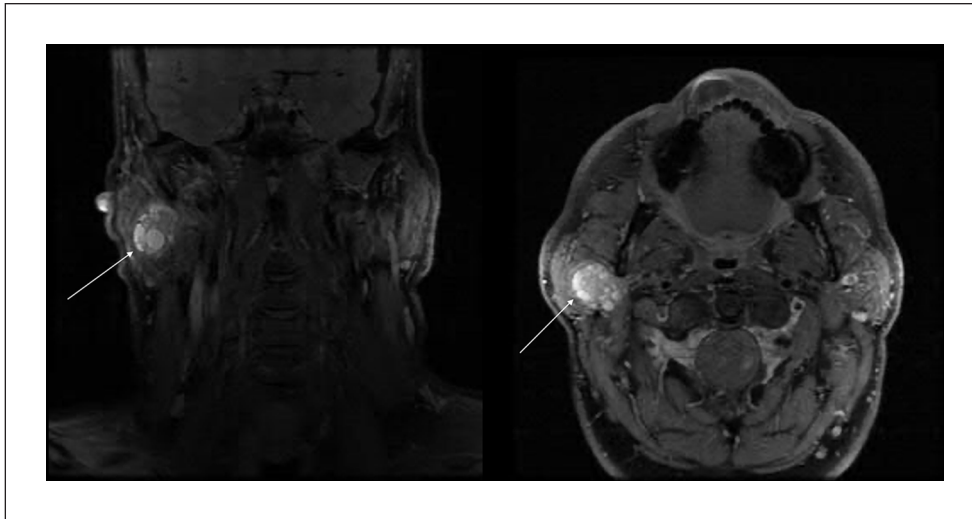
T1, fat suppressed, post-contrast coronal and axial MRI images of the right-sided secretory carcinoma, diagnosed in 2009. Arrows indicate the tumor, which appears to be a complex cystic and solid mass in the deep lobe of the parotid gland, sharply defined relative to the surrounding parotid. No regional adenopathy was noted.
